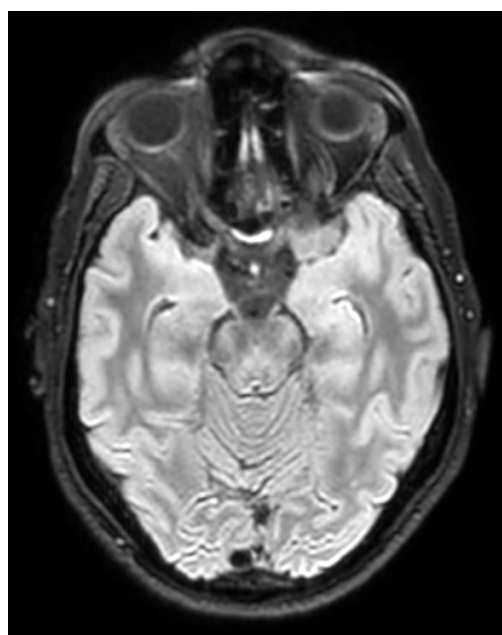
Brain MRI - axial
